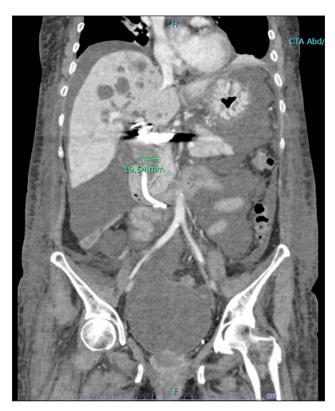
Coronal computed tomography image showing dilated extrahepatic duct with previous biliary stent and innumerable hepatic lesions.
